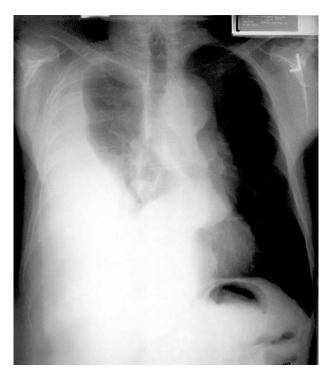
Chest x-ray taken preoperatively showing the aneurysm and right-sided hemothorax.
